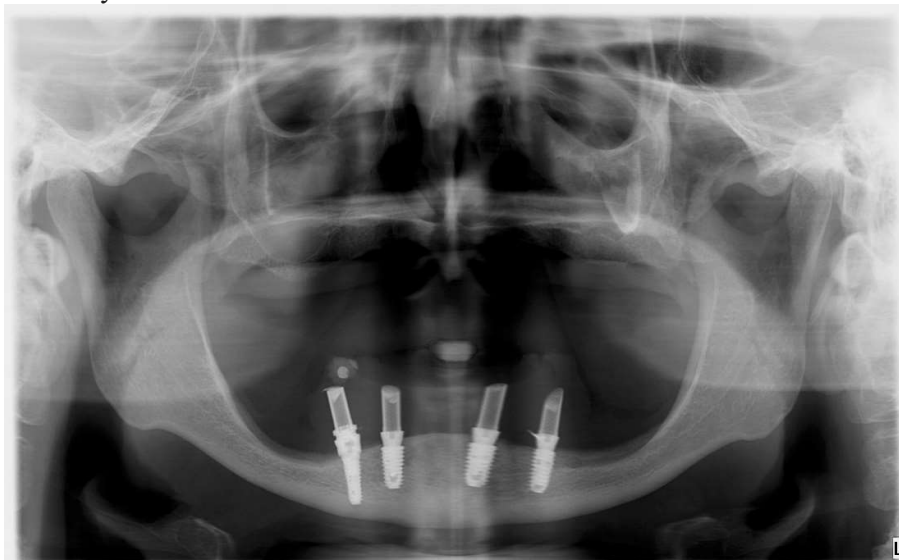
Case 4: panoramic radiograph at the 5-year follow-up.
